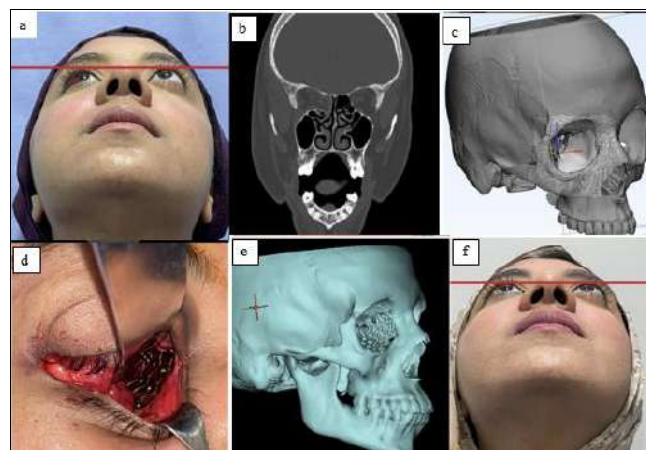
(a) Basal view of the patient showing right sided enophthalmos and conjunctival hemorrhage. (b) Coronal CT cut showing extension of the orbital contents near the nasal septum. (c) The planning model with dimensions in x, y and z axis which was used in adapting the mesh. (d) Intraoperative looks after adapting the titanium mesh to cover medial orbital wall. (e) 3D model showing restored medial orbital wall. (f) Normal look of the patient after one month of surgery.
